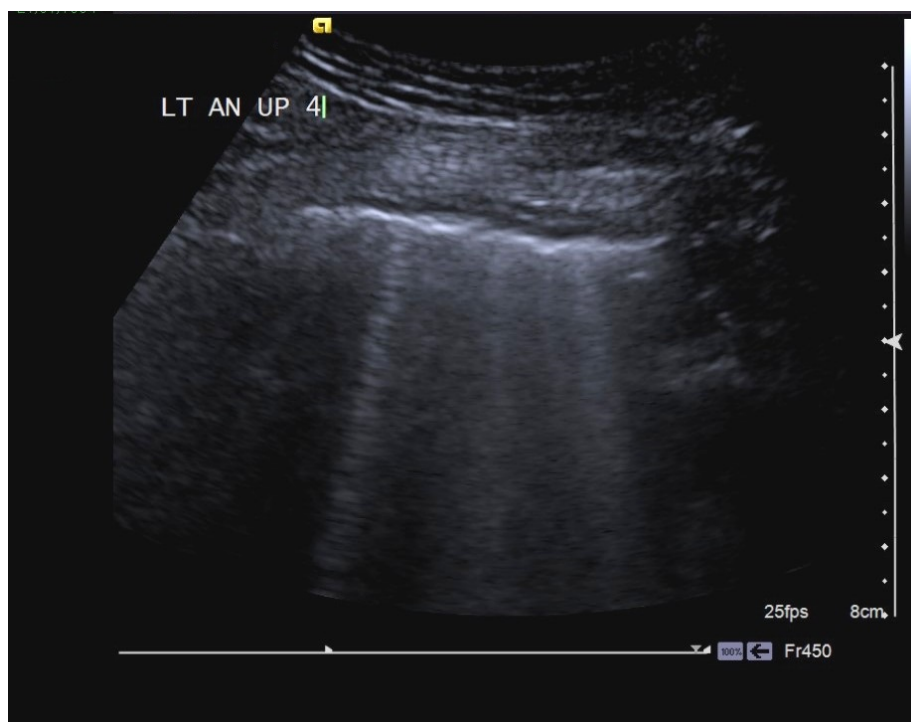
b – Anterior view of the lungs from a patient with AIS: Sonographic pattern of comet-tail artefacts fanning out vertically from the lung-wall interface and spreading up to the edge of the screen (B-lines).
